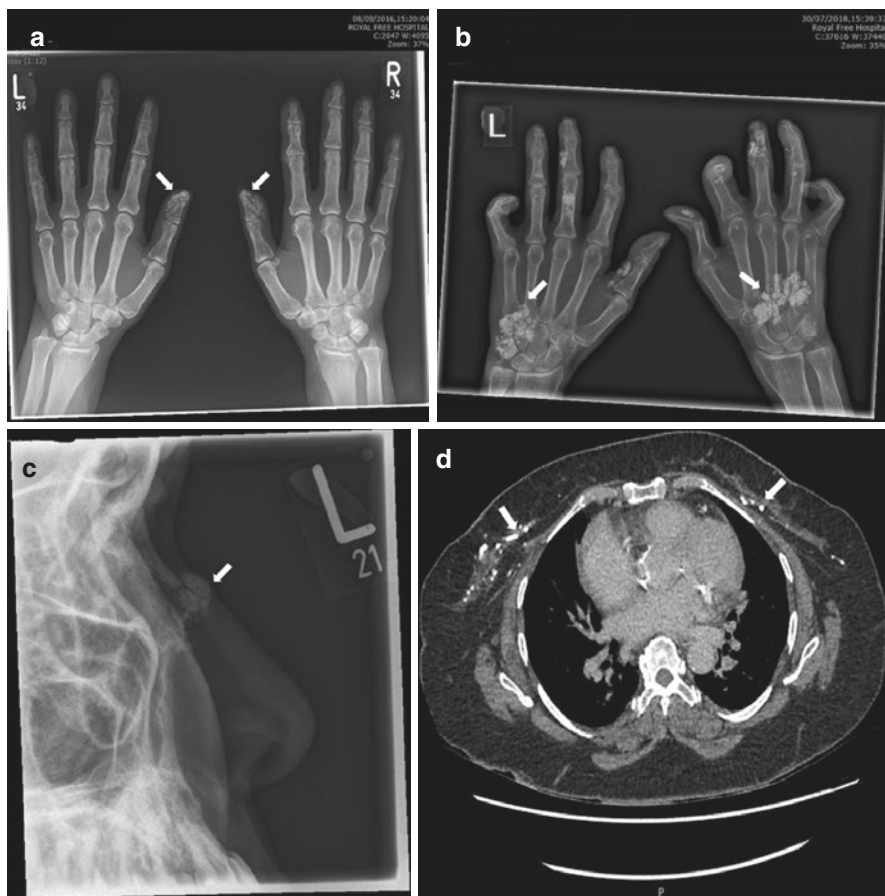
Radiologic appearance of calcinotic lesions in systemic sclerosis. (a) Typical calcinosis affecting the distal finger pulps in limited cutaneous SSc with severe Raynaud's. (b) More extensive lesions affecting the carpus as well as phalanges and associated with flexor contractures. (c) Atypical sites may also be involved as in this lesion affecting the bridge of the nose. (d) CT of thorax showing subcutaneous calcinosis of anterior chest wall. Arrows indicate areas of calcinosis
